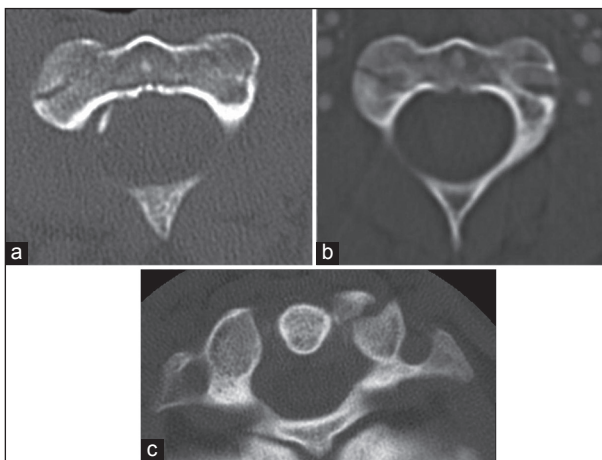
(a) Axial computerized tomography (CT) of c-spine shows a right C2 lateral mass fracture without significant fragment evolution. (b) CT angiogram of the neck shows a right C2 lateral mass fracture with extension across the associated foramen transversarium. (c) CT of c-spine shows a left C1 lateral mass fracture with modest fracture displacement
